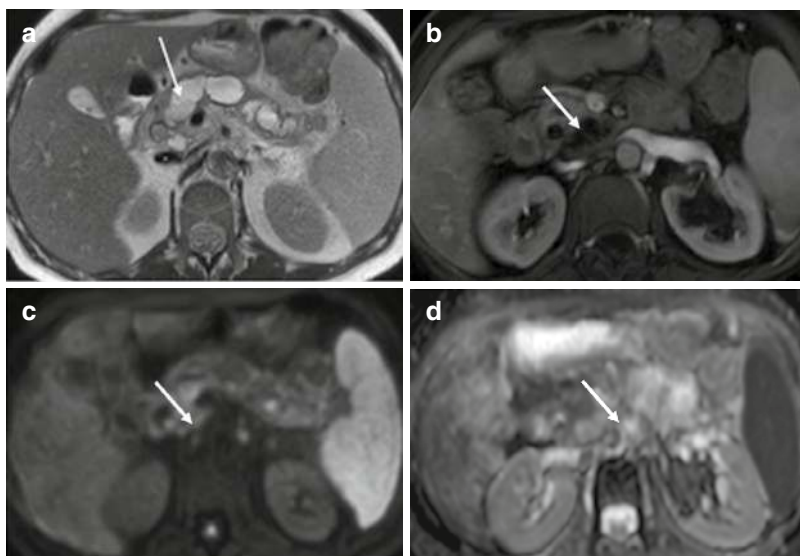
A 67-year-old woman with MD-IPMN with signs of degeneration. (a) T2-weighted image shows a hypointense solid tissue (arrow) inside the dilated main pancreatic duct. (b) In the arterial phase, enhancing the solid tissue is visualized (arrow). On DWI (c) the solid tissue is hyperintense (arrow) with restricted diffusion in the Apparent Diffusion Coefficient map (d) (arrow)
